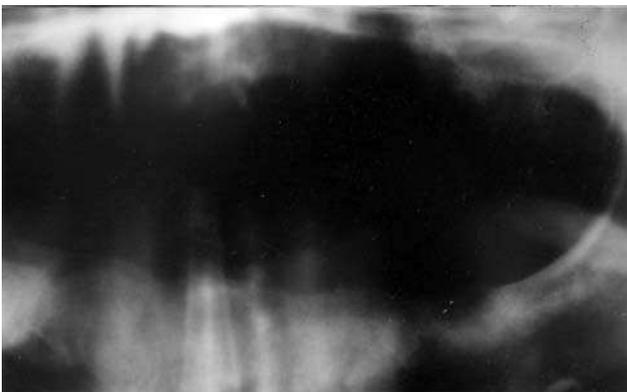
Panoramic radiograph showing the absence of the osteoma in the maxillary region
